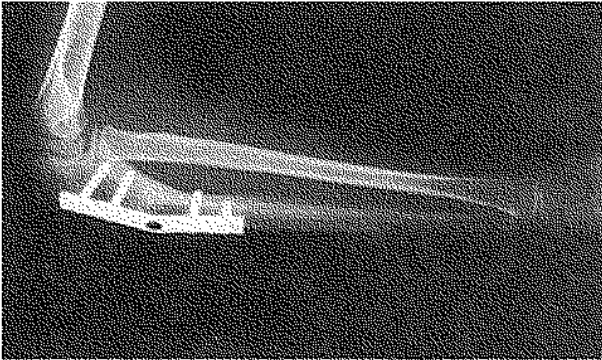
Lateral radiograph of an elbow after osteotomy of the ulna, stabilised with a plate and screw fixation. The radial head is reduced and the physiological ulnar bowing has been restored.
